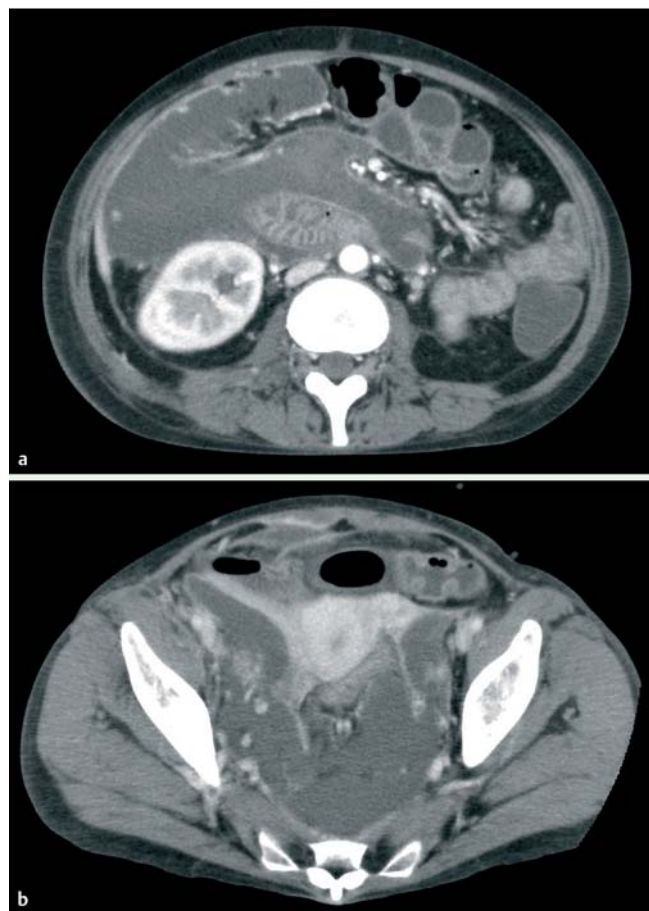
A contrast-enhanced computed tomography (CT) scan showed extensive walled-off pancreatic necrosis (WOPN): a upper abdomen, b pelvic region.
